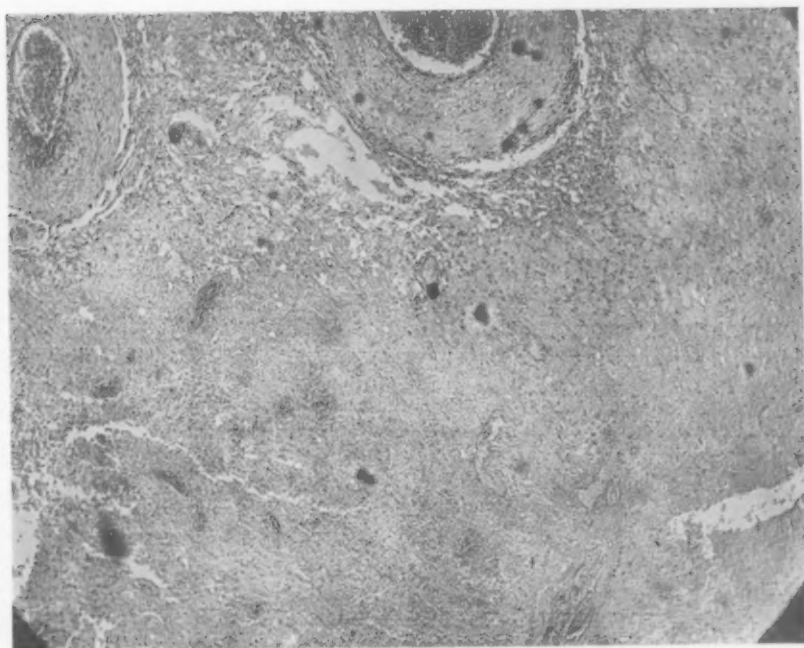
Same tumor as Fig. 7 after intensive X-ray therapy. There is extensive necrosis with marked thickening of the vessel walls not unlike the vessel changes in syphilis. These changes in the vessels not seen before X-ray was instituted.
